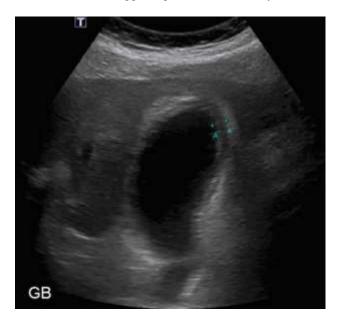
Abdominal Ultrasound scan.
